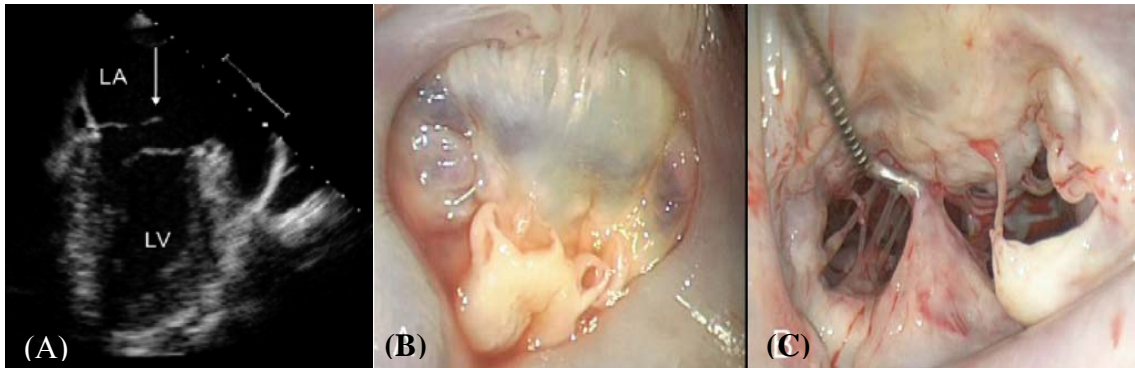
(A) Echocardiograph of the prolapsing mitral valve in a patient with fibroelastic deficiency. Unlike Barlow's disease that presents with significant leaflet billowing, chordal rupture in this case results in complete movement of the prolapsing leaflet into the left atrium, developing a large regurgitant orifice; (B) Myxoid changes to the prolapsing posterior mitral leaflet after chronic regurgitation, though the myxoid changes and leaflet thickening were isolated to the prolapsing segment; (C) Surgical view of the ruptured marginal chordae that caused the prolapse [ Images courtesy of Dr. David Adams, Mt Sinai School of Medicine, NY]
